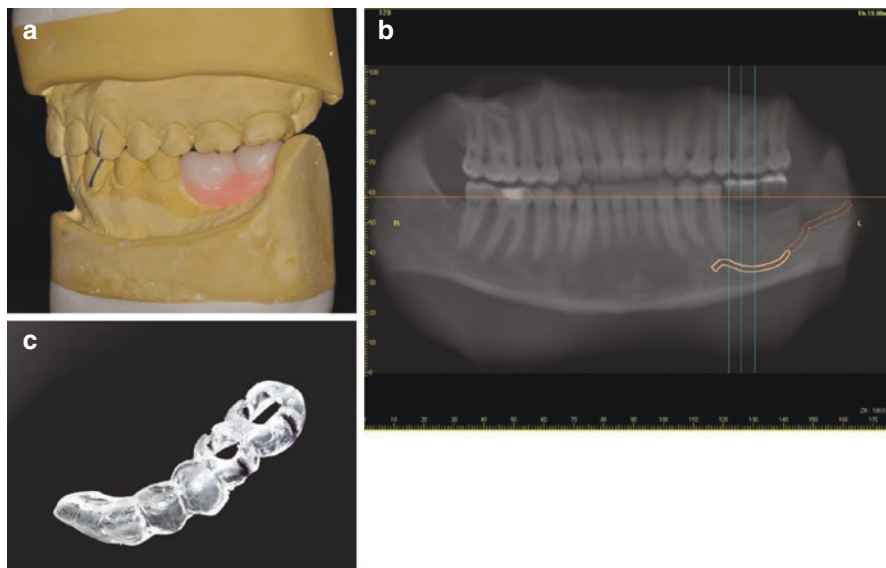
The basic components needed for proper treatment planning of implant cases. (a) Mounted diagnostic casts with denture teeth waxed into correct position of the final implant crowns. (b) A panoramic view of a CBCT showing the radiographic guide with radiopaque material within the image. (c) Surgical guide made through modification of radiographic guide by removing radiopaque material and placing holes at implant placement sites
